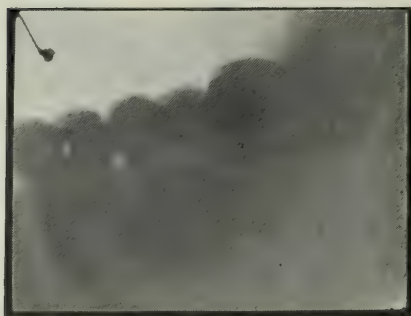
This slide shows a condition we often find. An inferior third molar, partially erupted, and causing much discomfort. Requested its removal, and (as the picture shows) it was fortunate for all concerned that X-Ray was taken. The tooth, with roots pointing directly back in the angle of the jaw, would without the picture have been almost impossible to remove, but, with it, operation was successful.
